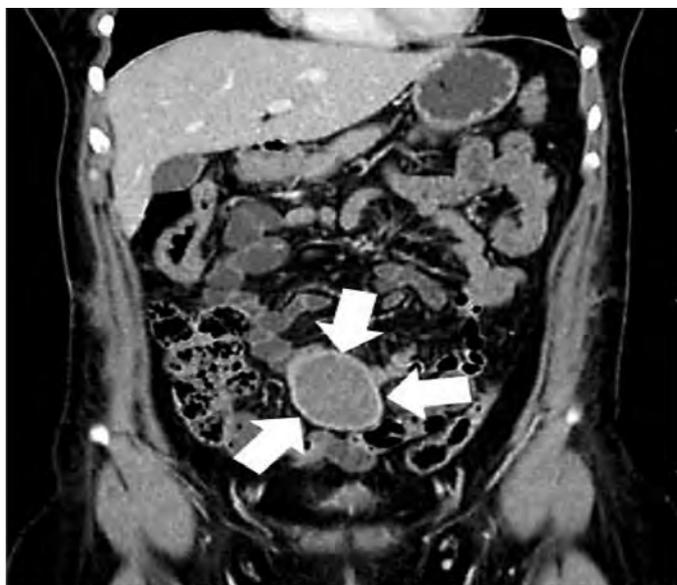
Case 2: A post-contrast coronal CT scan revealed a rounded, encapsulated mass in the pelvis, almost in the midline. Note the dense capsule with enhancement on the post-contrast study (arrows).
